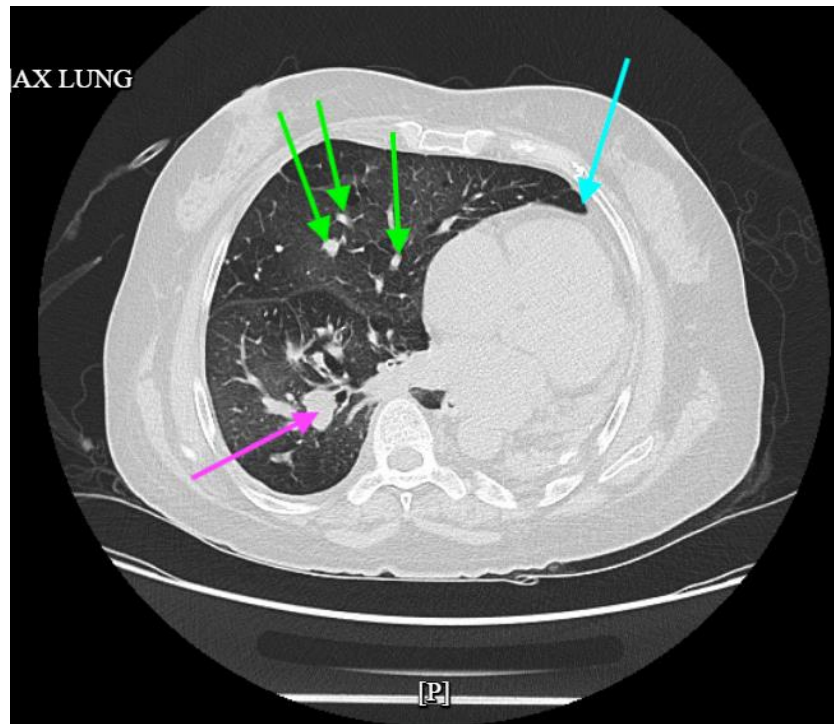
Non-contrast CT chest.
